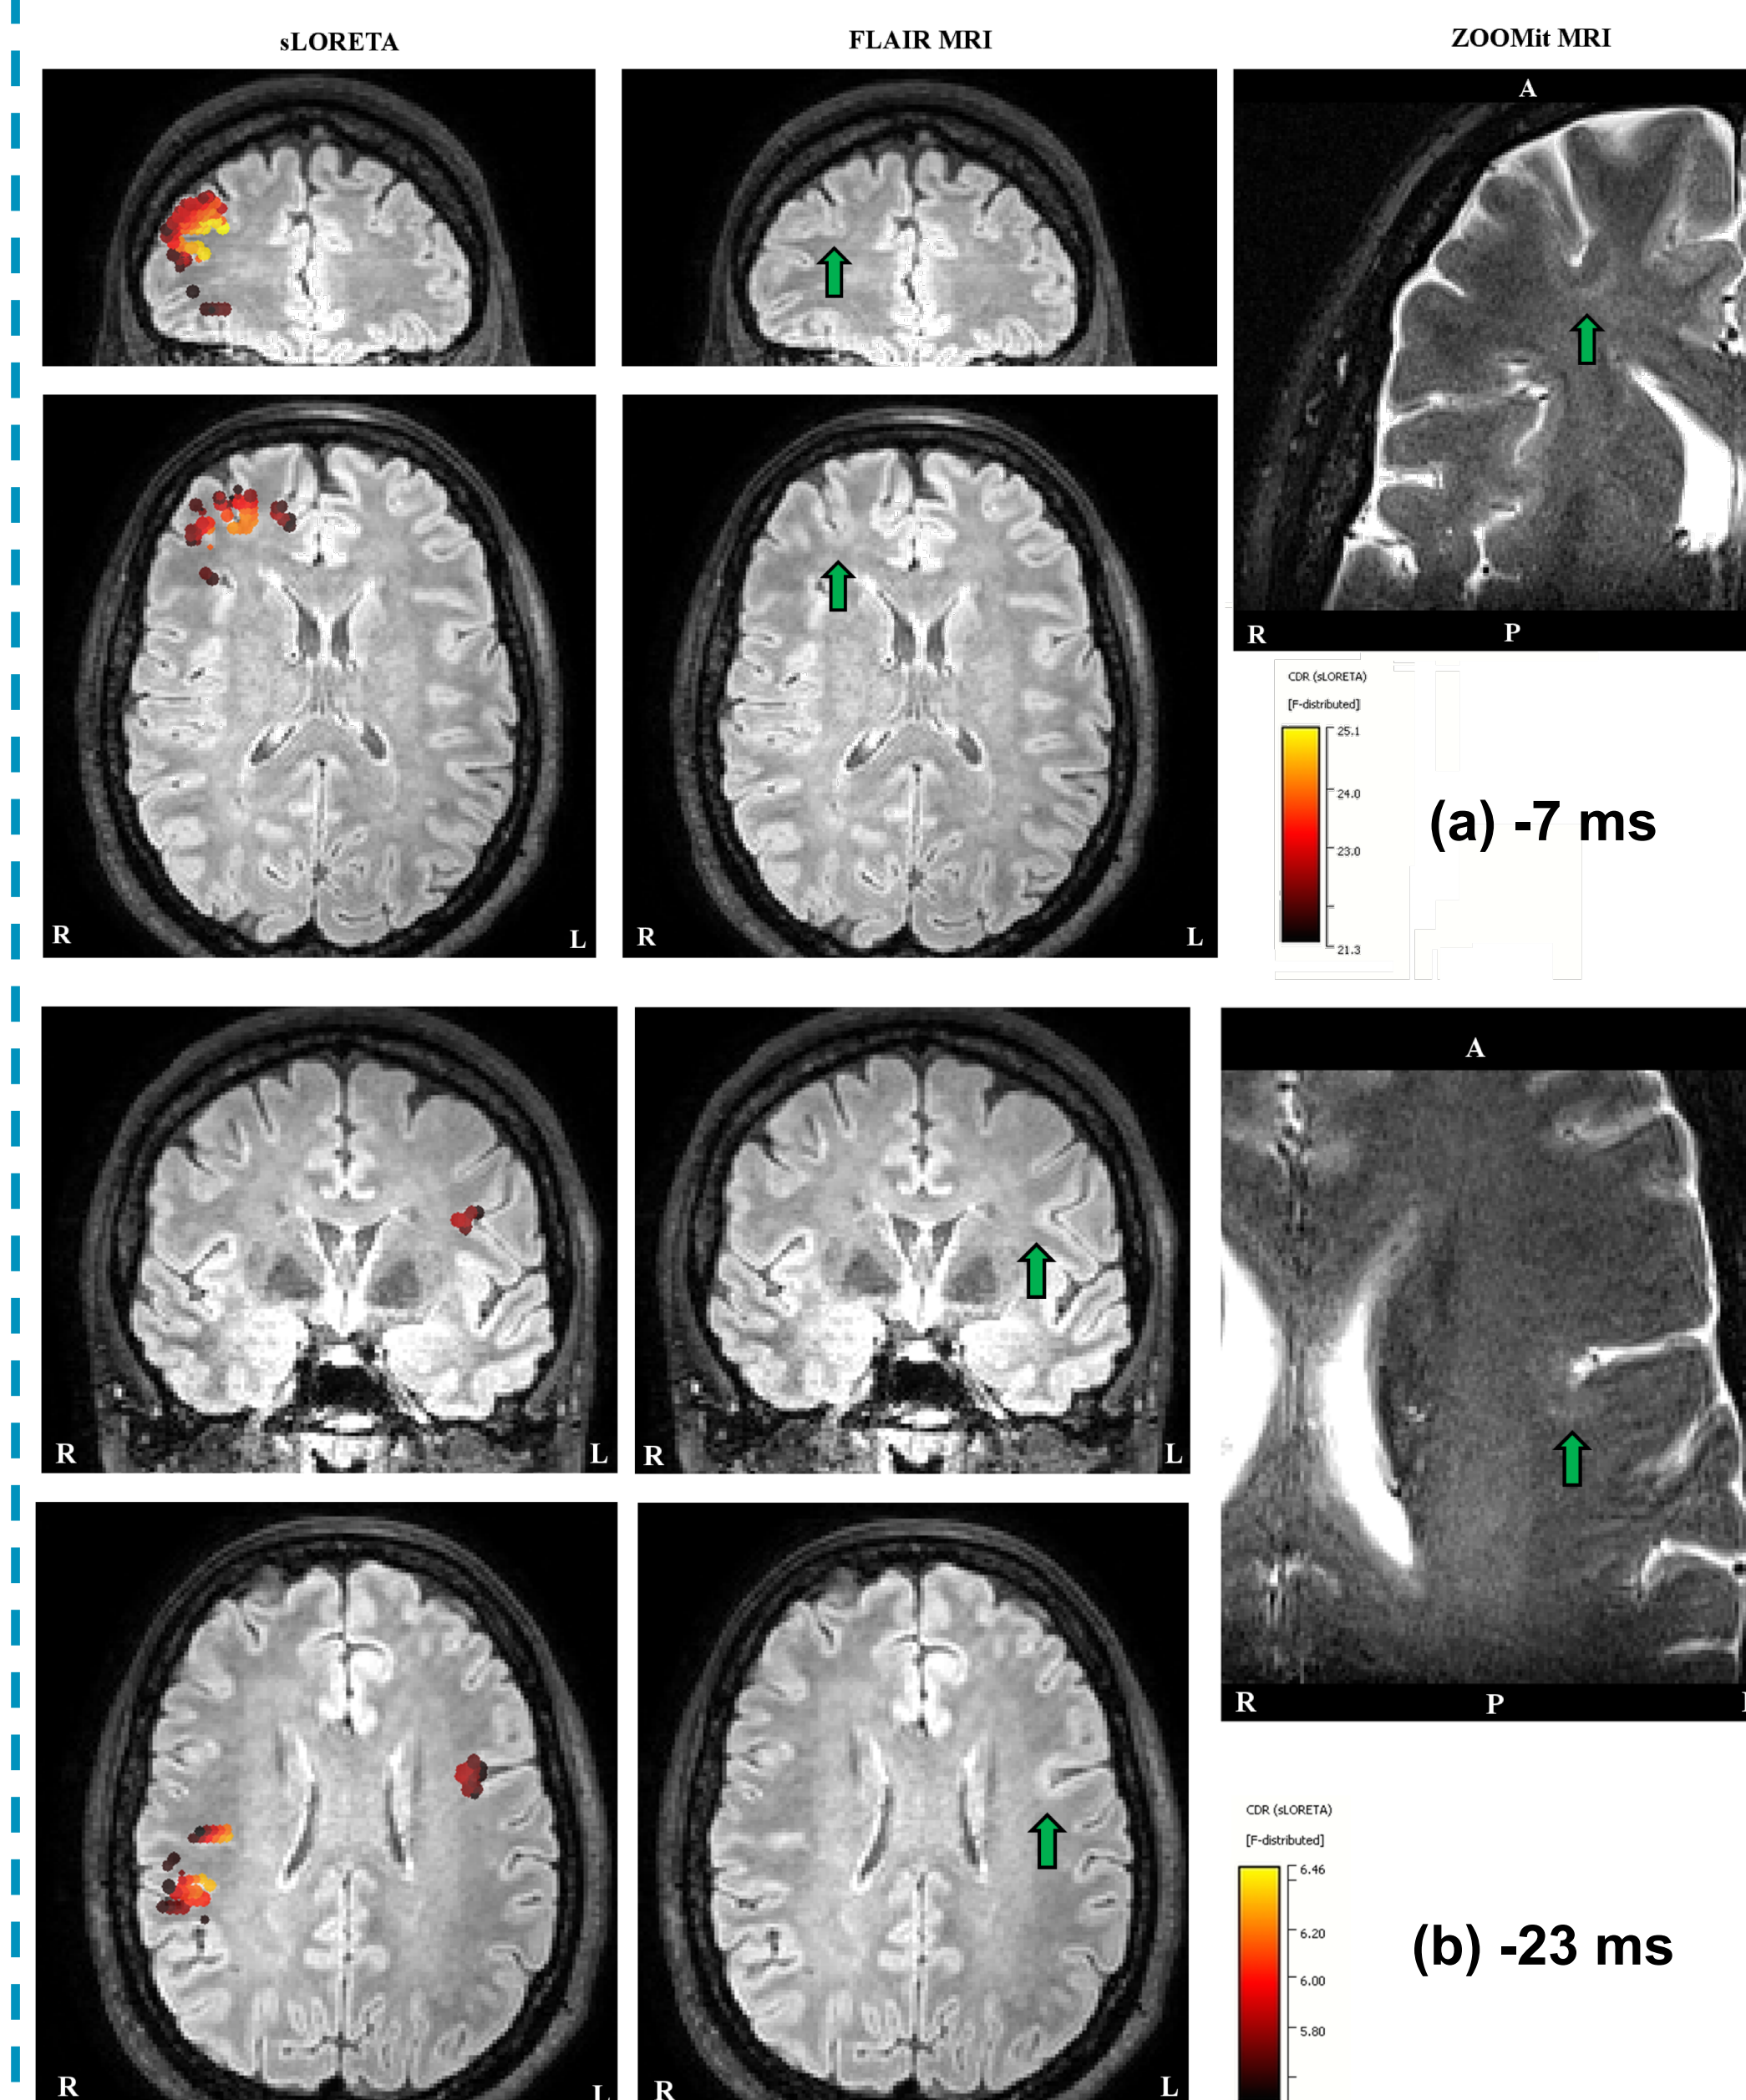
EMEG source analysis at (a) -7 ms and (b) at -23ms. Left columns: the sLORETA results projected onto the FLAIR MRI (only results obtained after a threshold of 85% for the maximum F-value). Middle columns: the FLAIR image without the localizations to enable the identification of the FCDs (pointed to by green arrows). Right columns: ZOOMit MRI with the green arrow indicating the FCD. (L left, R right, A anterior, P posterior).
